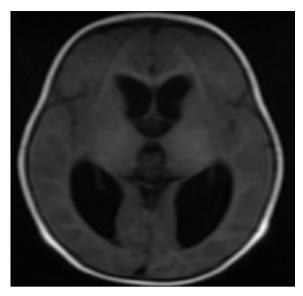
T2 flair MRI brain axial-depicting prominently dilated lateral ventricles.
